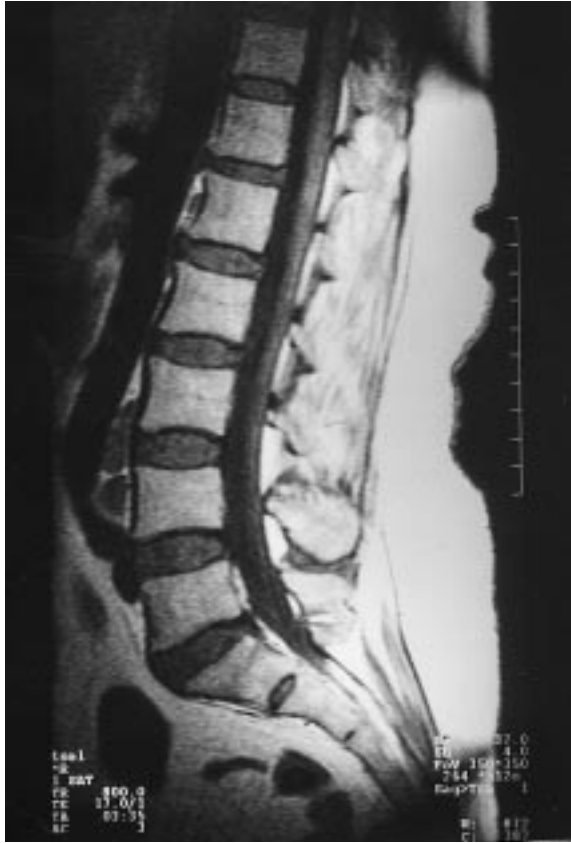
Normal MR findings of bone marrow on T1-weighted images.
